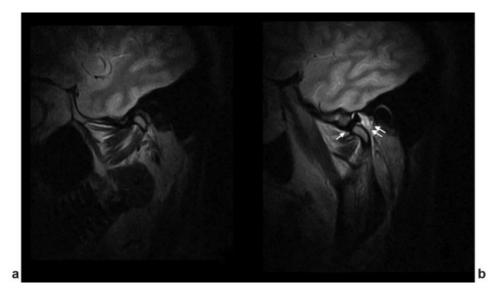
Left temporomandibular joint examination on weight-bearing magnetic resonance Imaging (the table is tilted 81 degrees). (a) Sagittal T2-weighted imaging sequence with the mouth closed shows edema of the caput superior of the lateral pterygoid muscle; the mandibular condyle in located in the glenoid fossa. (b) Sagittal T2-weighted imaging sequence with the mouth open of the same patient shows the articular disk locked in the glenoid fossa (arrow); an intra-articular fluid collection is also present (double arrow).
